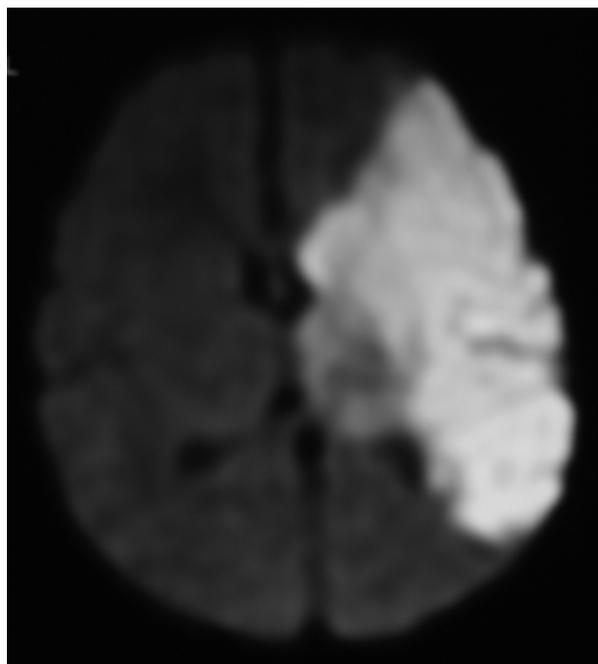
Magnetic resonance image (MRI) of the infant's head with diffusion-weighted imaging. This image intensifies and defines the affected area better than MRI alone.
